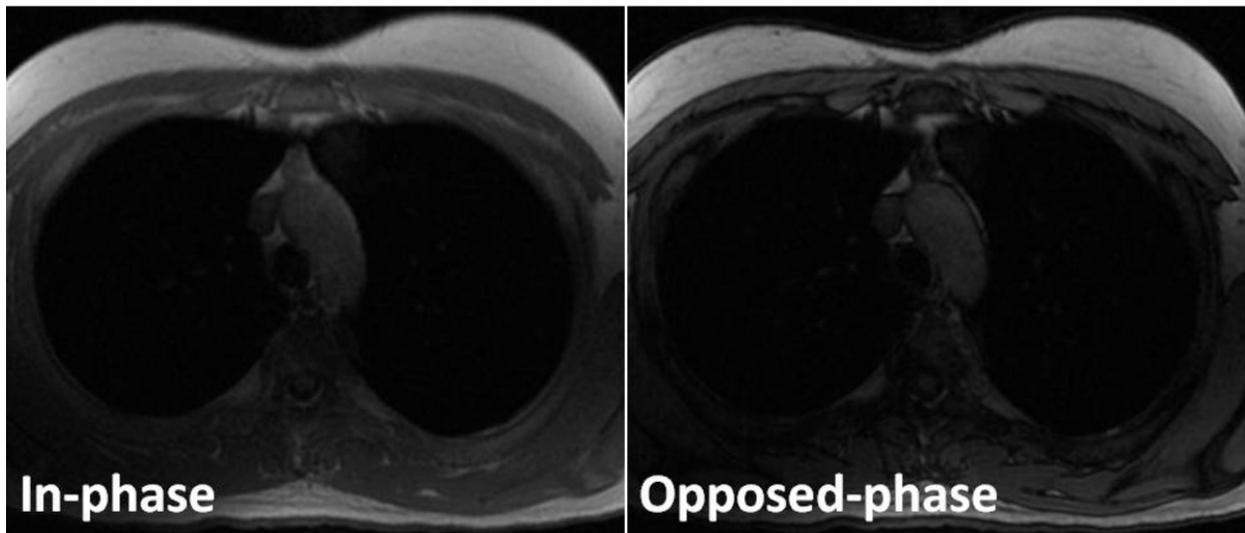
Thymic hyperplasia in a 26-year-old men with myasthenia gravis. Transverse in-phase (155/4.6) and opposed-phase (155/2.1) gradient-echo T1-weighted MR images demonstrate an apparent decrease in signal intensity of the thymus gland on the opposed-phase image relative to the in-phase image. The CSR is 0.331.
